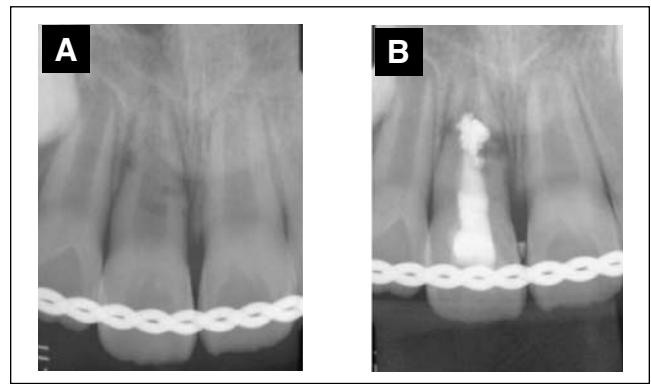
Intra-oral radiograph of maxillary anterior teeth after 2 month of treatment.
